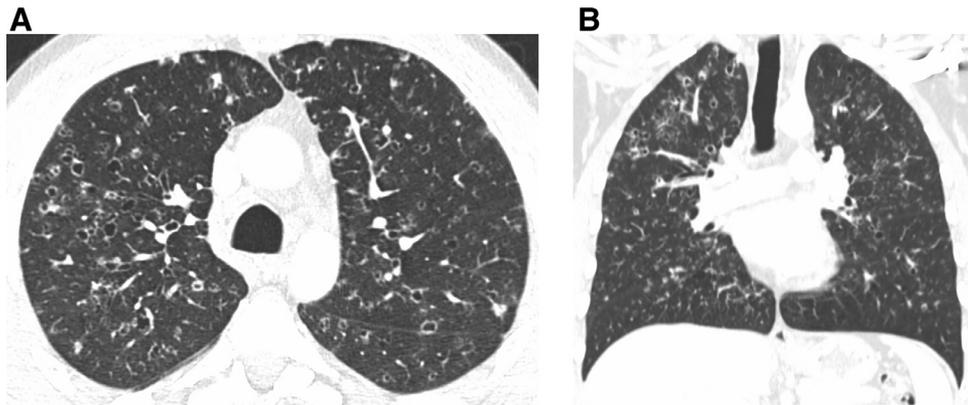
A 44-year-old male smoker with pulmonary Langerhans cell histiocytosis. Axial (A) and coronal reformatted (B) CT images show upper lobe predominant nodules and irregular cysts. Note the conspicuous sparing of the costophrenic sulci.
